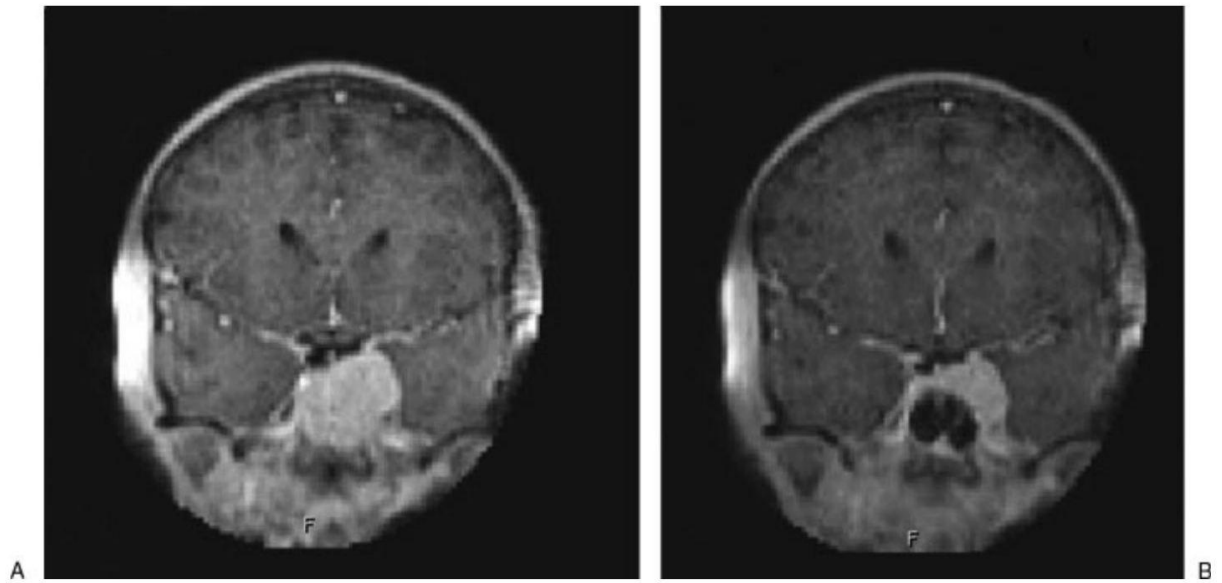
intraoperative MRI scans (PoleStar N20, 0.15 T, Medtronic Navigation) of the combined procedure.
